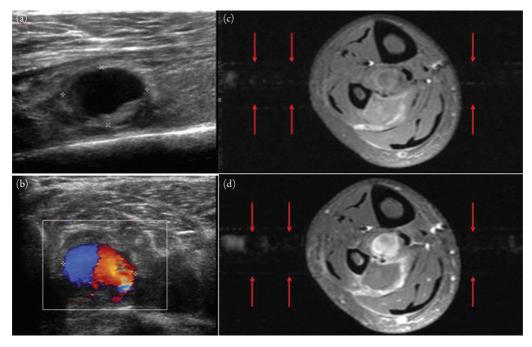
Pseudoaneurysm. Panel (a) shows a gray-scale sonographic image in transverse plane of a palpable intra-muscular mass in the leg. The mass is mainly anechoic with posterior acoustic enhancement. On color Doppler evaluation, the mass has significant internal flow with the typical "yingyang" appearance of a pseudoaneurysm (Panel (b)). Companion axial magnetic resonance (MR) images prior to (Panel (c)) and following IV contrast (Panel (d)) show a partially enhancing bi-lobed intramuscular soft tissue mass with MR pulsation artifact (arrows). Pulsation artifact is a helpful MR imaging artifact used to confirm that the mass is vascular.
